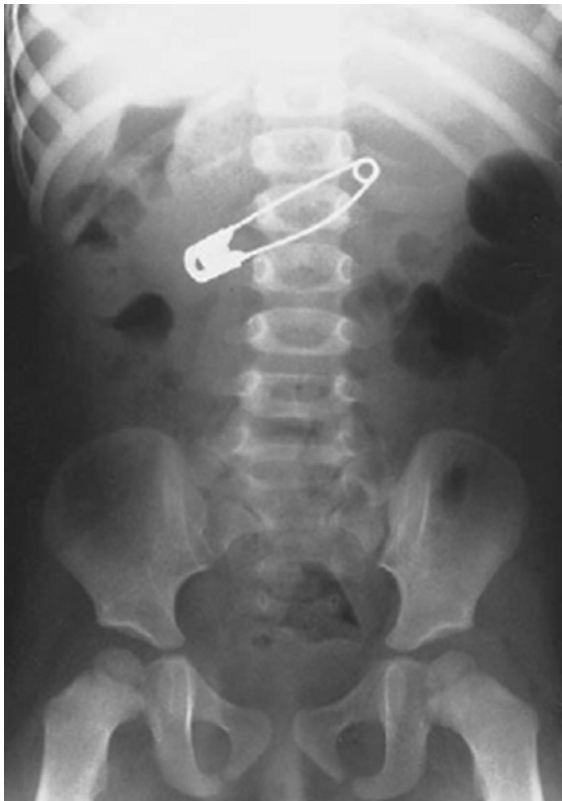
Abdominal x-ray showing a safety pin in the stomach. This should pass spontaneously.
